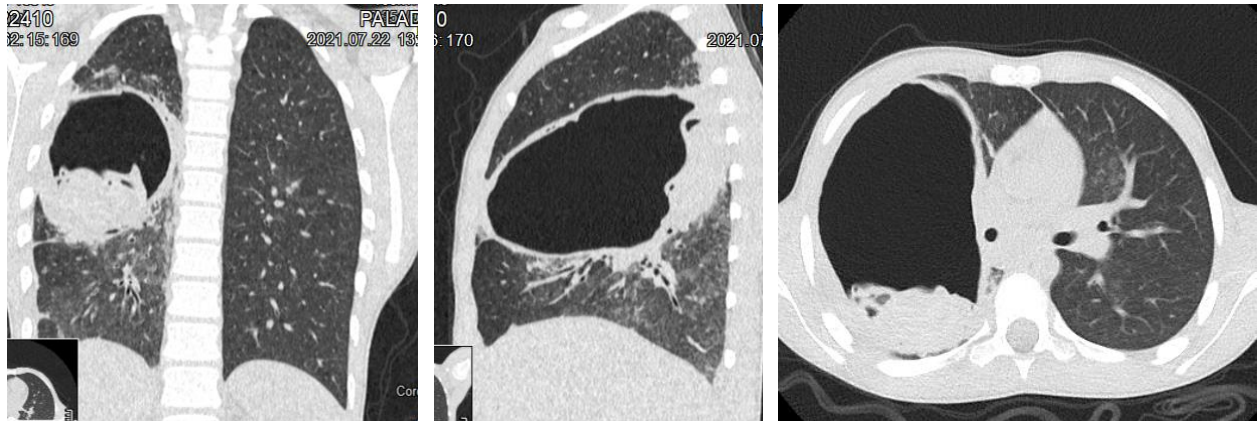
Patient P.A., 11 years old. Preoperative CT: hidatid pulmonary cyst with endobronchial eruption situated in middle lobe of right lung. The floating membrane sign is displayed.
